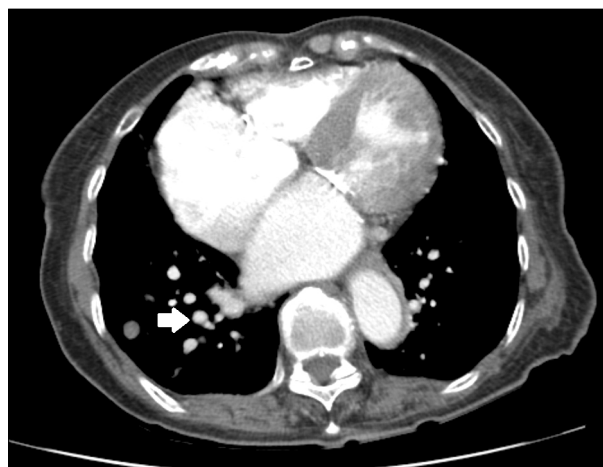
Chest CT findings. Axial CT scan shows suspected arteriovenous malformation (arrow) in pulmonary vasculature suggesting pulmonary involvement in a patient.
